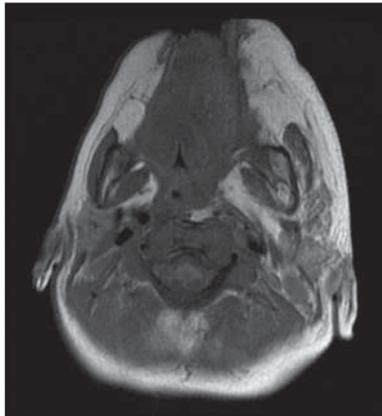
Axial T1-weighted fast spin-echo magnetic resonance imaging. Note asymmetric enlargement of left hemitongue and fatty infiltration of left cheek (bright).
